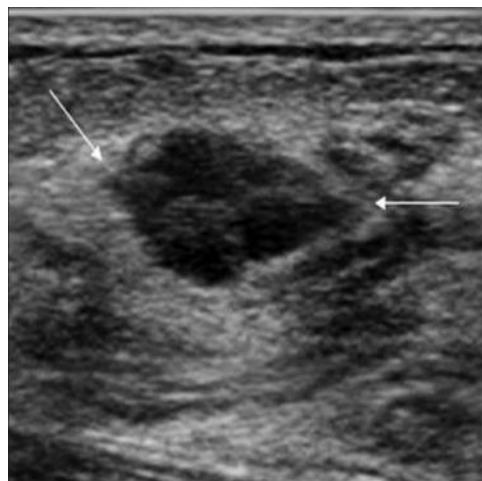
Ultrasound of case (2).
